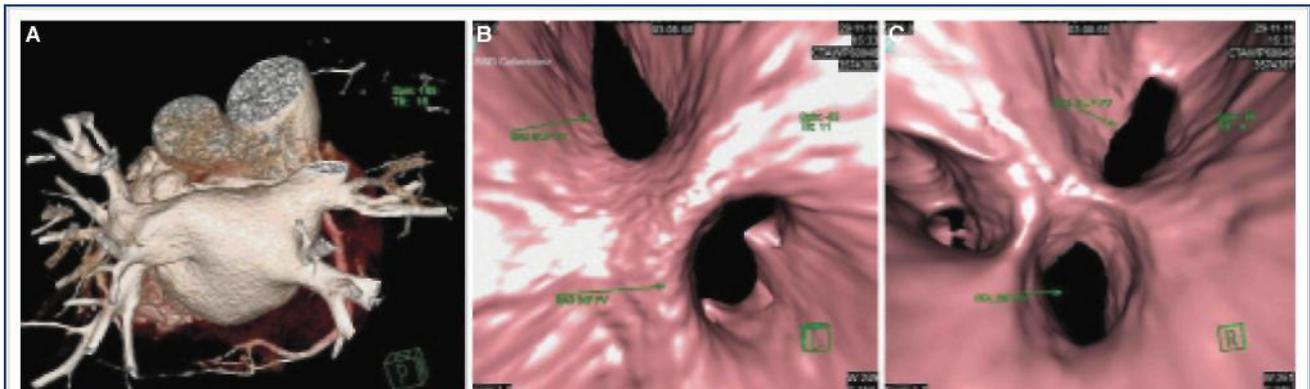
Evaluation of the pulmonary vein anatomy using multislice computed tomography (A) 3-D reconstruction of the left, and the right pulmonary veins as seen through anteroposterior window (B) Endoscopic, and 3-D volumetric reconstruction demonstrating right lower, and upper pulmonary veins
